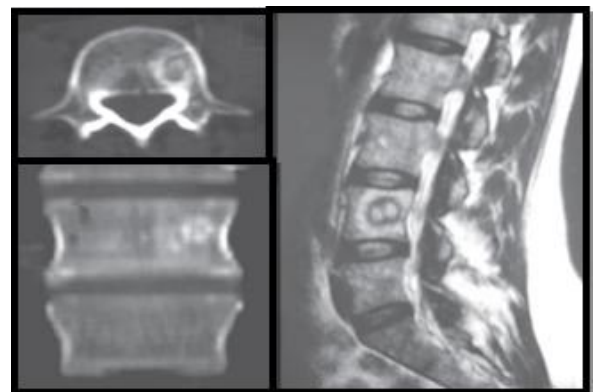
(Case 2): CT & T2W MR images showing a nidus with mild adjacent sclerosis in body of L4 vertebra.
